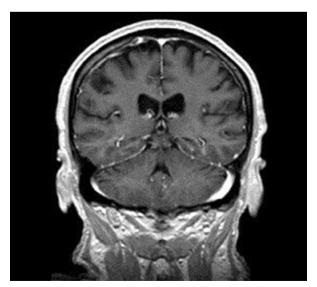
Magnetic resonance tomogram in the coronal plane in the FLAIR sequence
